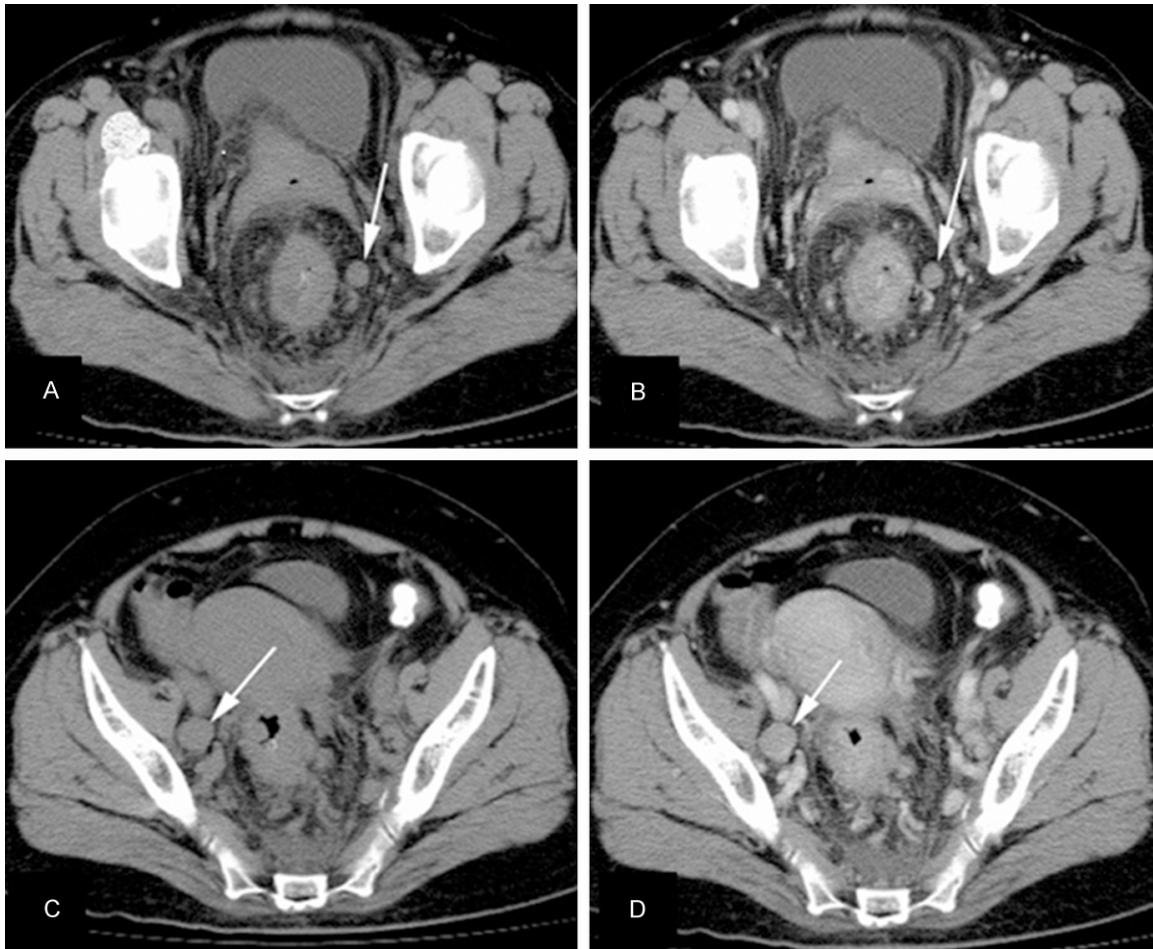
Computed tomography scans of regional lymph nodes (A, B: Arrows) and lymph nodes near the right iliac vessels (C, D: Arrows) showing metastases from rectal cancer.
